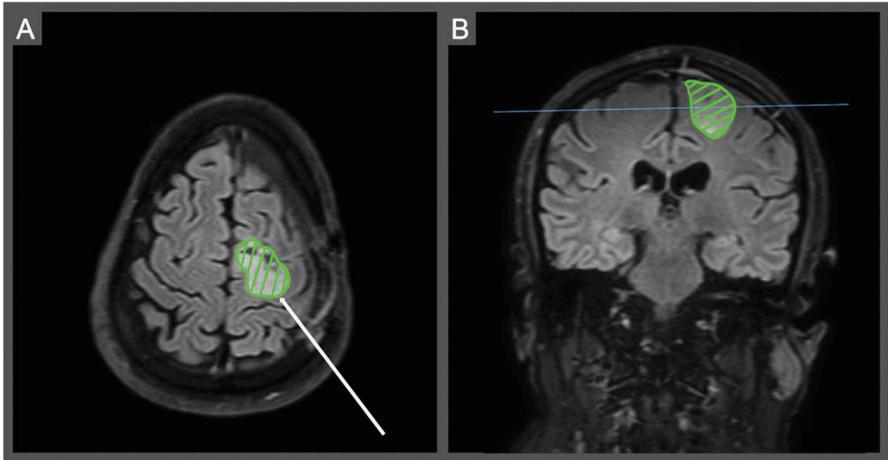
Pre-operative axial and coronal views. The left and right images are T2-weighted fluid-attenuated inverted recovery (FLAIR) axial and coronal (respectively) MR images from the patient's pre-operative work-up. This sequence is useful for lower grade and poorly enhancing gliomas. The hyperintense region is well demarcated and signifies the span of the patient's lesion. The arrow in image A is pointing to the suspected motor cortex.
